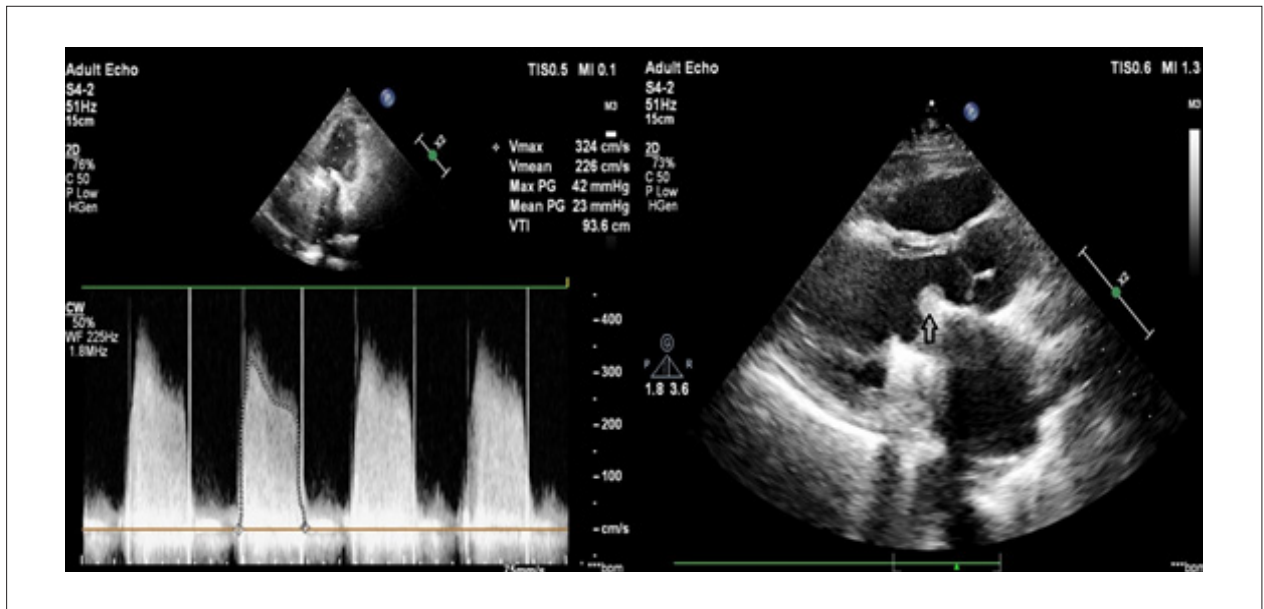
Echocardiographic images of obstructed mechanical valve.
